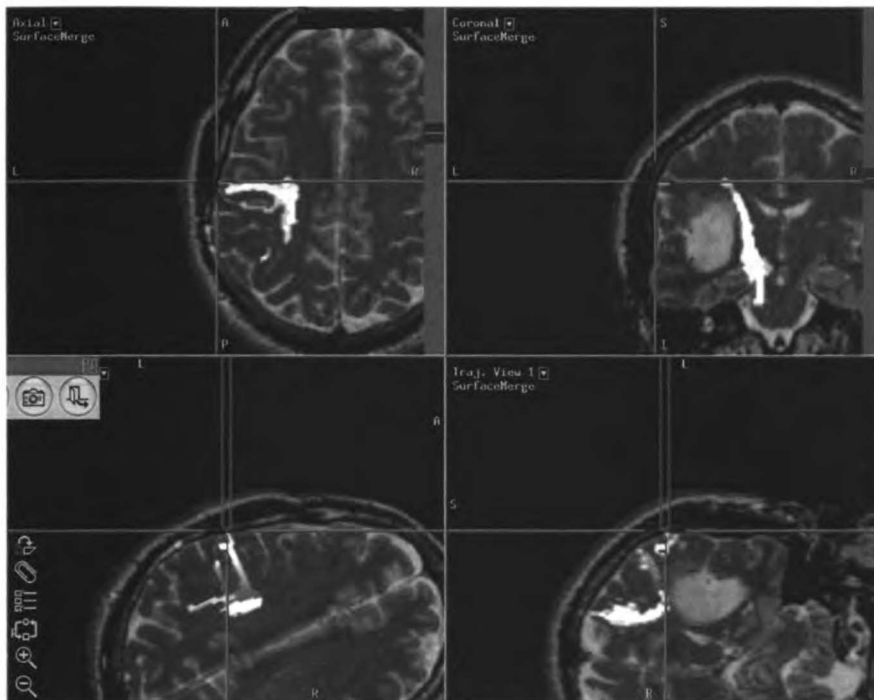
Screen capture from the surgical navigation system. The crosshairs indicate the location of a jaw motor site. Bright white pixels on the MR images indicate the DTI fiber tracks generated prior to surgery. Images are oriented in the neurological convention.
